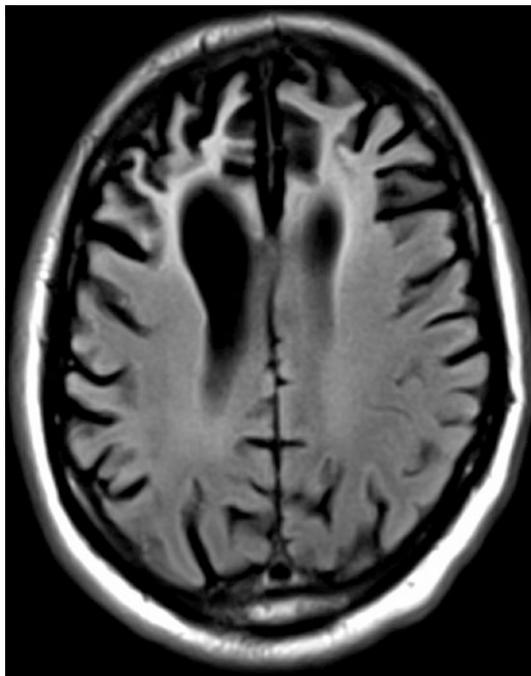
FLAIR-MRI (*axial view*). Note knife-like cortical atrophy of frontal areas
